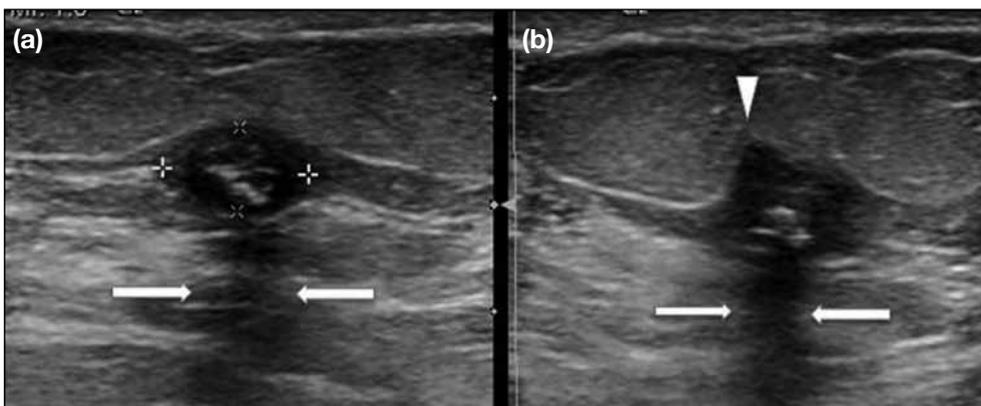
Ultrasound images of the right upper outer breast lesion taken in the (a) radial and (b) antiradial plane, show the irregular margin superiorly with the 'calcification' and posterior shadowing BI-RADS 4 assignment. The lesion is 0.7 cm x 0.4 cm in size (calipers), with an irregular margin (arrowhead). Posterior shadowing cast by the lesion is also shown (arrows).
